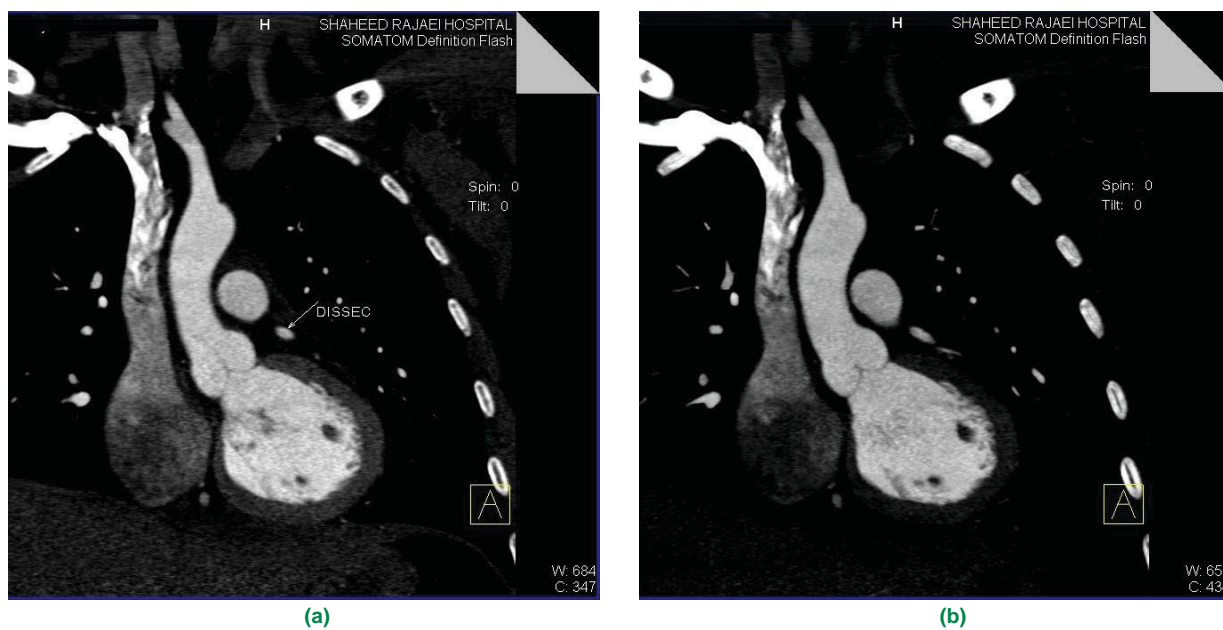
a, b) Cross-sectional CT imaging of the left descending coronary artery at the proximal and middle segments: at the proximal portion, there is thrombosis of the false lumen. Segment B shows double lumens.
